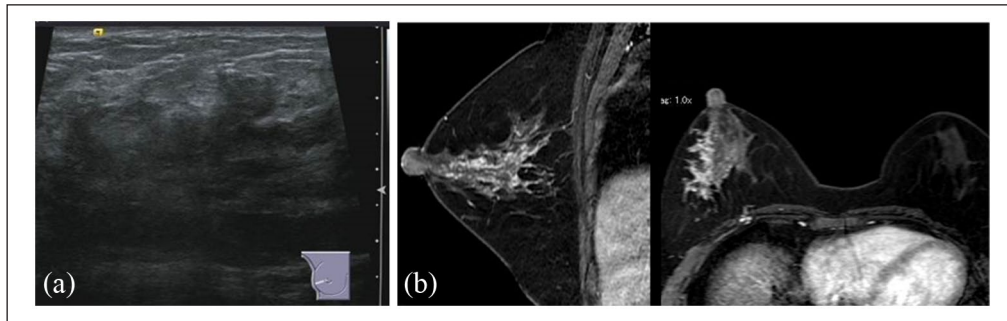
(a) Ultrasonography shows a hypoechoic area in the lateral region of the right. (b) Magnetic resonance imaging shows enhanced lesions in the lateral region of the right breast.
